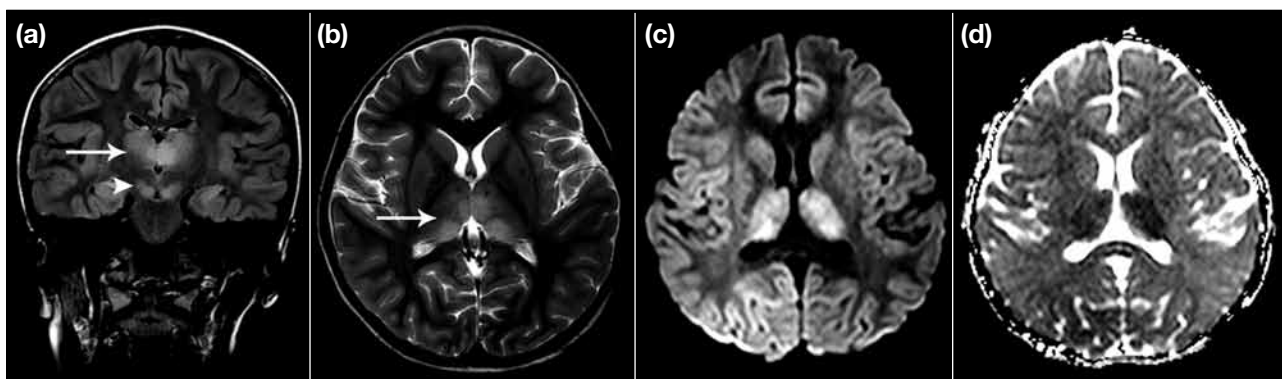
Bilateral thalami (arrow) and brainstem (arrowhead) lesions are hyperintense on (a) fluid-attenuated inversion recovery magnetic resonance image, (b) T2-weighted image, and (c) diffusion-weighted image, and are hypointense on (d) apparent diffusion coefficient map, indicative of restricted diffusion. The lesion extent score was 3.
